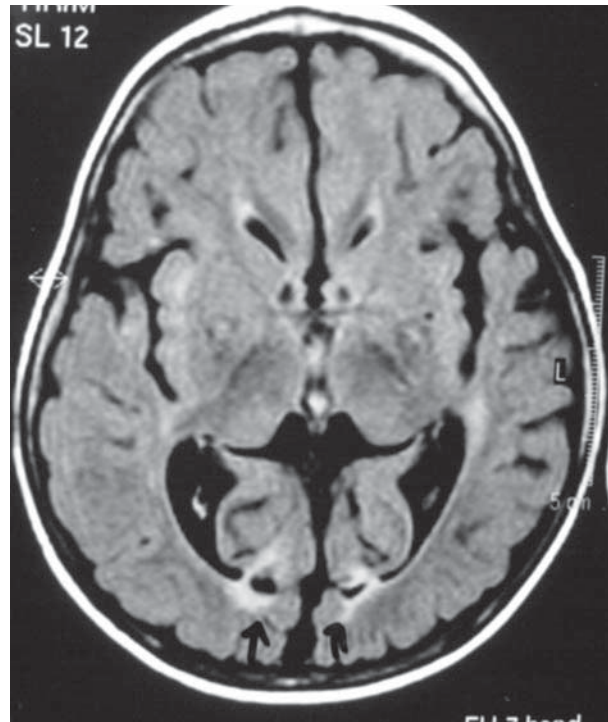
Bilateral occipital lesions typical of neonatal hypoglycemic brain injury (MR FLAIR image).
